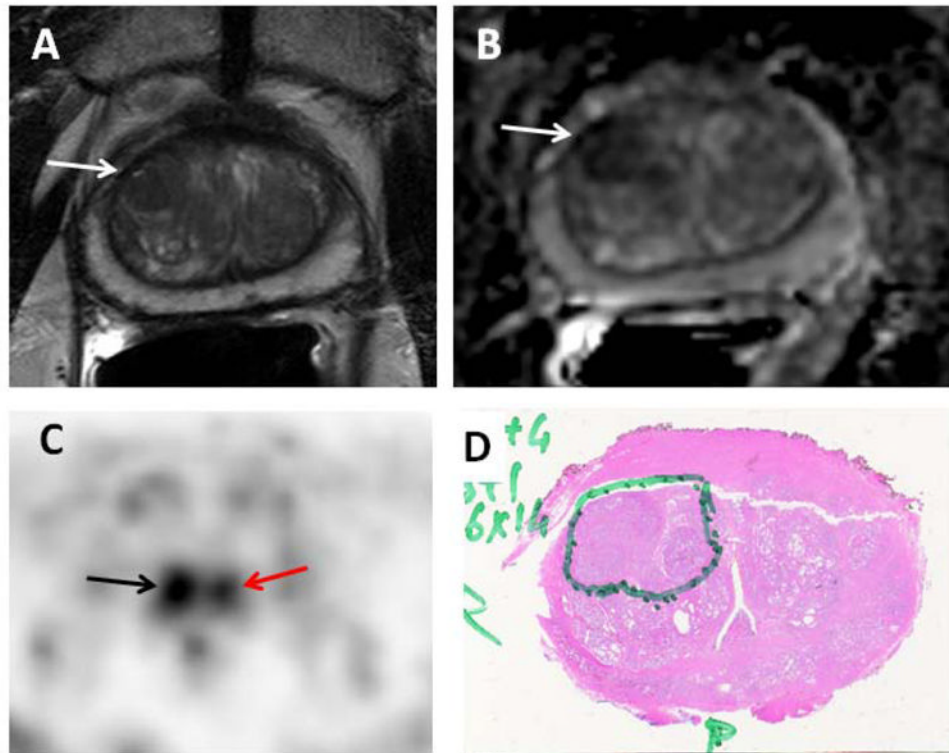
69 year-old-male with prostate cancer. Axial T2-weighted MRI (A) and ADC map (B) show focal low signal intensity in the right mid-anterior central gland (white arrows), which demonstrates increased ^{11}C -acetate uptake (black arrow) (C). Corresponding pathology (D) confirms the presence of tumor (Gleason 4+4), inked in green. Focal ^{11}C -acetate uptake in the left central gland corresponds to a BPH nodule (red arrow) (C).
